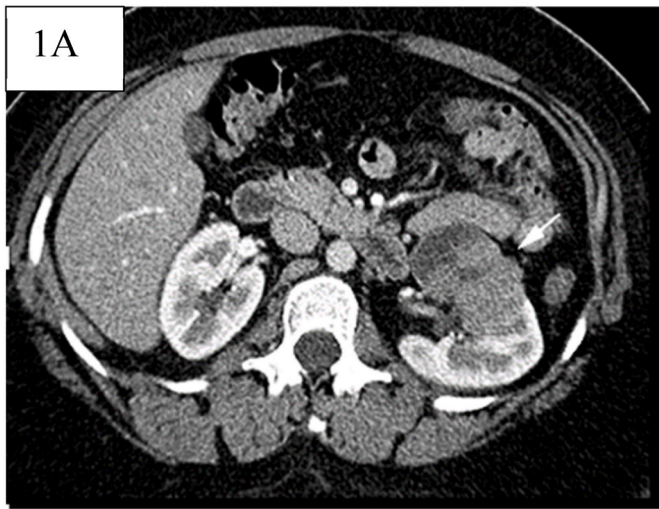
CT from 2010 with intravenous contrast. Tumour is seen in the left kidney (white arrow).
